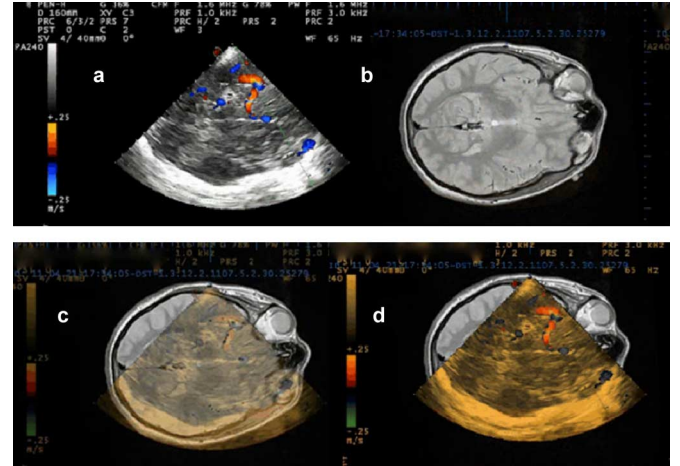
Internal vessel landmarks (middle cerebral artery) used for the manual registration adjustment and for checking the final registration quality. The US image is shown in (a), the MRI is shown in (b) and the fusion is shown in (c) and (d) with progressive decrement of US transparency. The current matching of the middle cerebral artery resulted after a registration with fiducial markers, followed by a 0.4 cm lateral manual shift of the US in the axial plane and 0.5 cm in the caudal direction.
